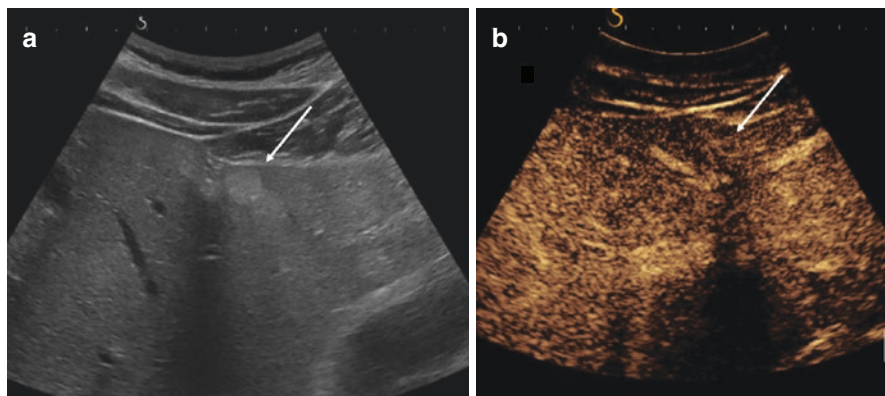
Atypical aspects of steatosis on ultrasound. Panel (a): focal fatty changes (FFC) can be multifocal and rounded in shape such in this case (arrow). Differential diagnosis with metastasis or angiomas is difficult, and a contrast-enhanced imaging technique is often needed (CEUS, CT or MR). Panel (b): In this case, CEUS was performed; the area showed ISO-enhanced in comparison to the rest of the parenchyma in the arterial, portal and late phase, confirming the diagnosis of FFC
